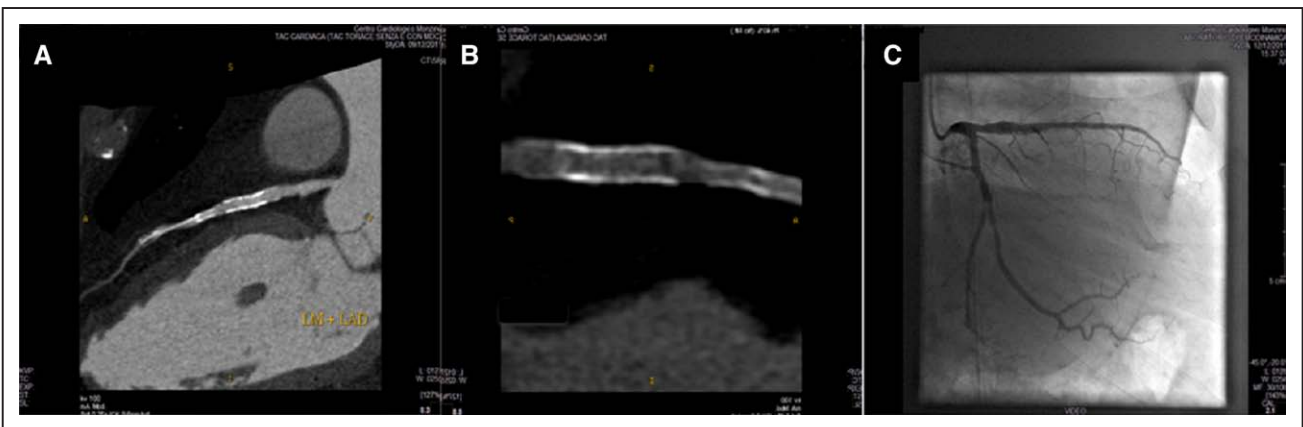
A 62-year-old man with known CAD and previous PCI (first diagonal branch and left anterior descending coronary artery stenting). Because of new onset substernal chest tightness, he underwent cTCA as first-line test that showed significant restenosis at the distal edge of the left anterior descending coronary artery stent (A and B). Invasive coronary angiography did not confirm cTCA findings (C). CAD indicates coronary artery disease; cTCA, computed tomography coronary angiography; and PCI, percutaneous coronary intervention.
